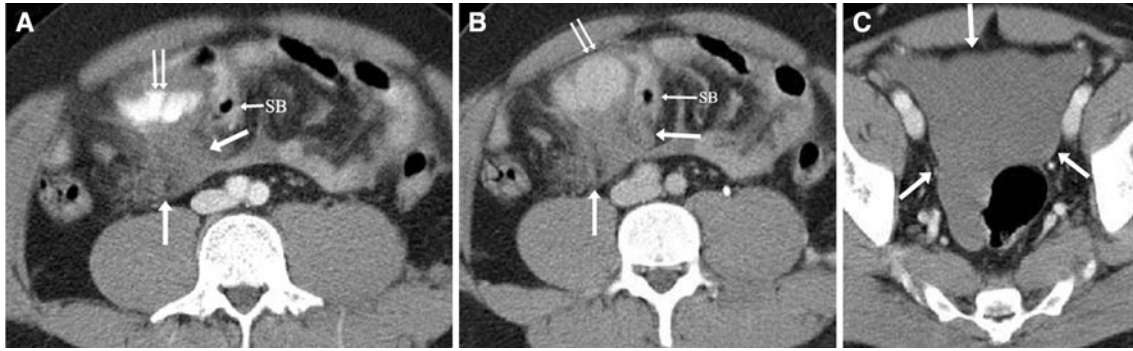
A 30-year-old male status post-blunt abdominal trauma. A Axial contrast-enhanced CT of the abdomen demonstrated active bleeding (*double arrows*) within a mesenteric hematoma (*arrows*). Adjacent small bowel (*SB*) is noted. B Delayed axial CT of the abdomen demonstrated increase in size and decrease in attenuation of the active
